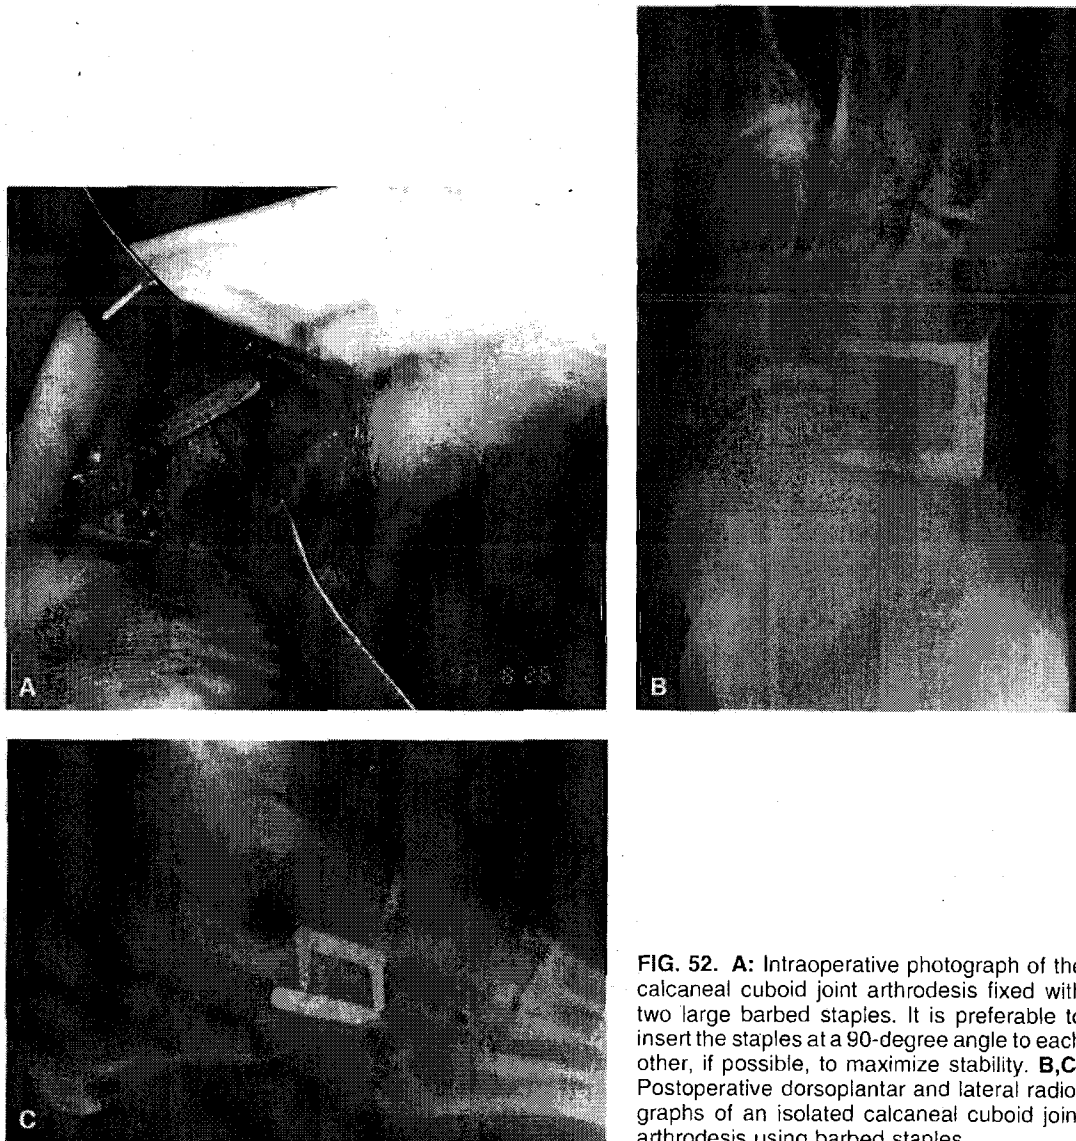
A: Intraoperative photograph of the calcaneal cuboid joint arthrodesis fixed with two large barbed staples. It is preferable to insert the staples at a 90-degree angle to each other, if possible, to maximize stability. B,C: Postoperative dorsoplantar and lateral radiographs of an isolated calcaneal cuboid joint arthrodesis using barbed staples.
